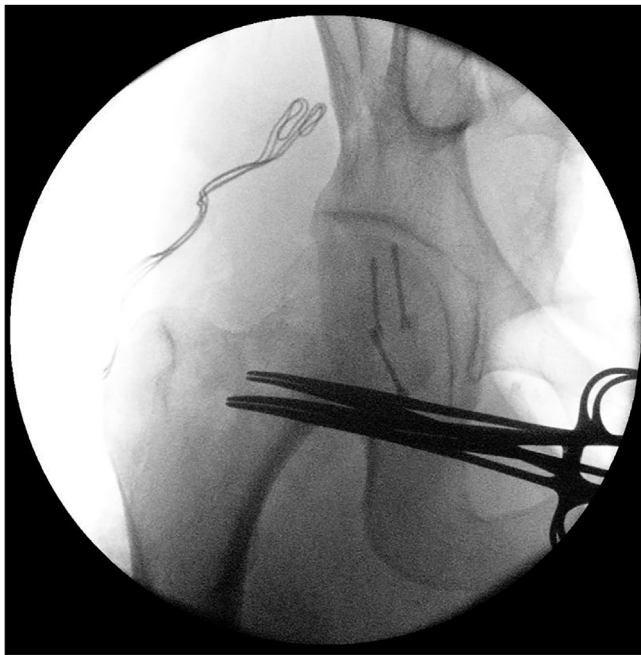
A. Intraoperative anteroposterior radiograph of the hip demonstrating femoral head fixation. B. Intraoperative anteroposterior radiograph of the hip demonstrating femoral neck fixation.
